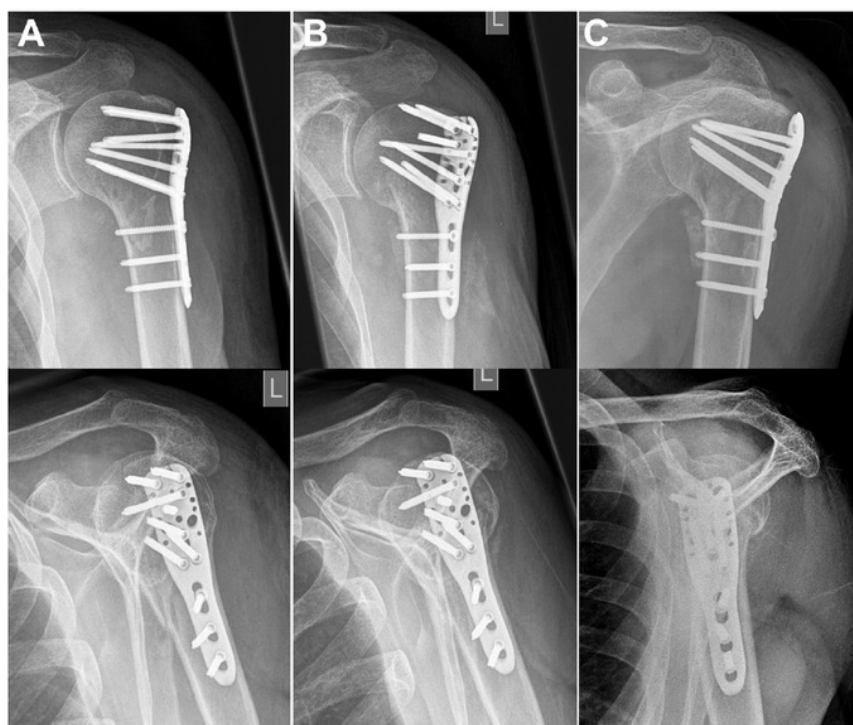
(A) Initial radiographs in anteroposterior and lateral views after open reduction and internal fixation of a proximal humeral fracture (AO11-A3) with a PHILOS locking plate (Synthes, Oberdorf, Switzerland) showing anatomic reduction and correct positions of the plate and screws. (B) Loss of fixation with varus dislocation of the head was noticed 6 weeks after the operation. (C) Bony healing after 6 months. The proximal screws have been removed at 3 months after the initial surgery.
